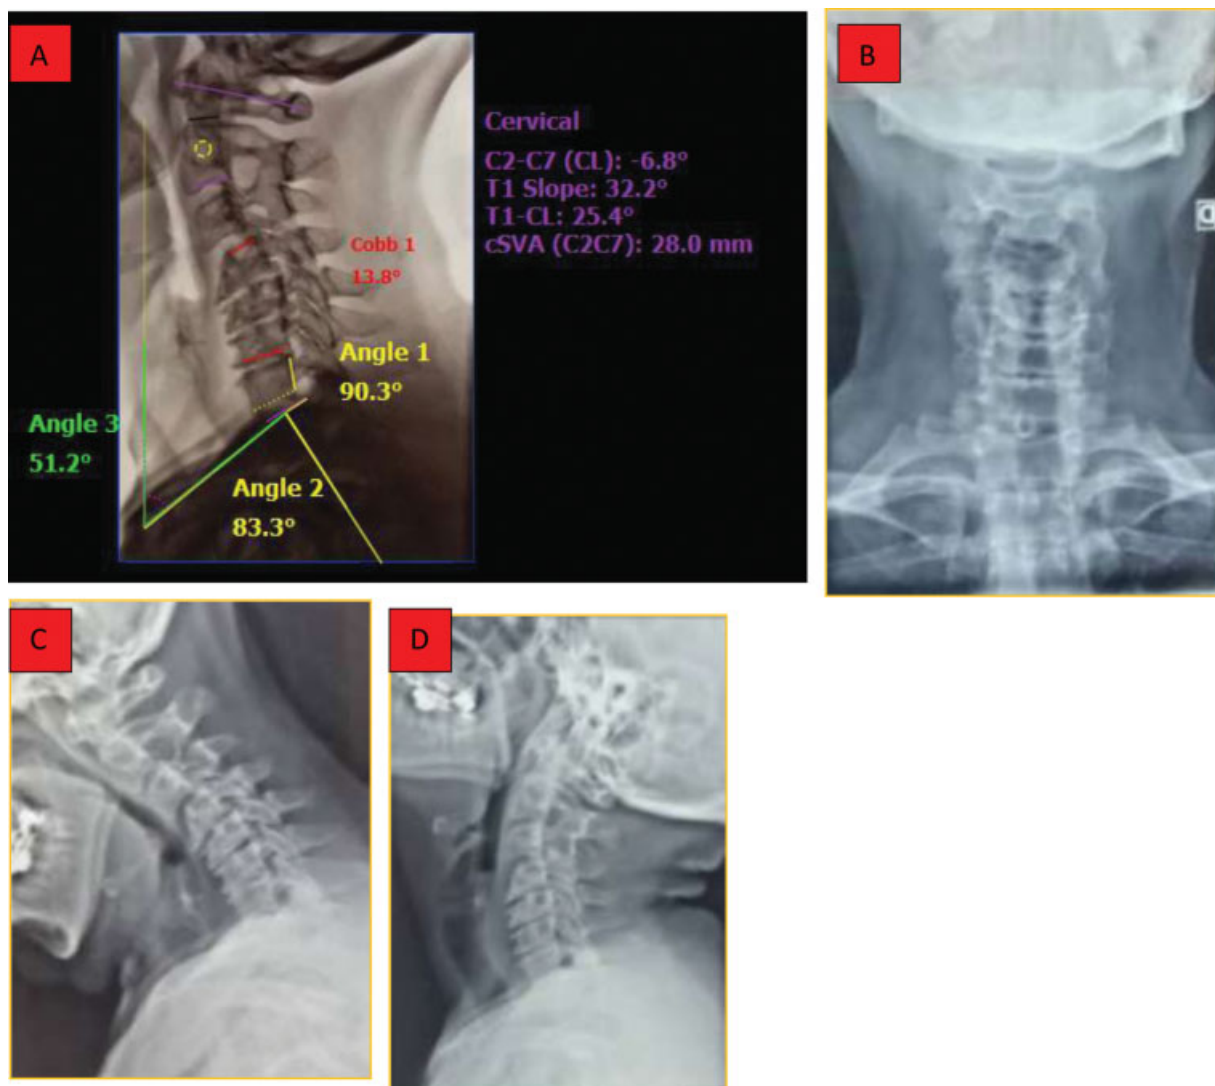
Radiographic parameters of cervical sagittal alignment. (A) Profile radiography with measurements of sagittal alignment of the cervical spine; (B) Radiography in anteroposterior incidence; (C) Radiography in profile with cervical flexion; (D) Radiography in profile with cervical extension; (E) Computed tomography of the cervical spine; (F-G) Magnetic resonance imaging of the cervical spine.
